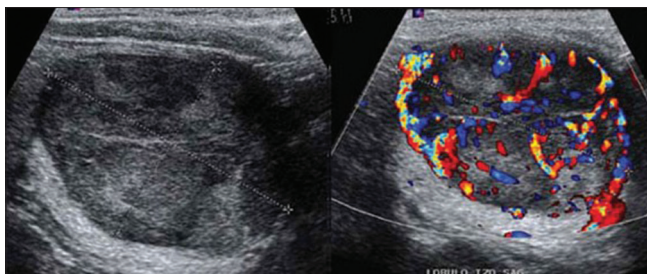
Transverse ultrasound scan shows a well-defined, homogeneous, solid iso-hypoechoic oval-shaped thyroid nodule, suggestive of a follicular lesion
